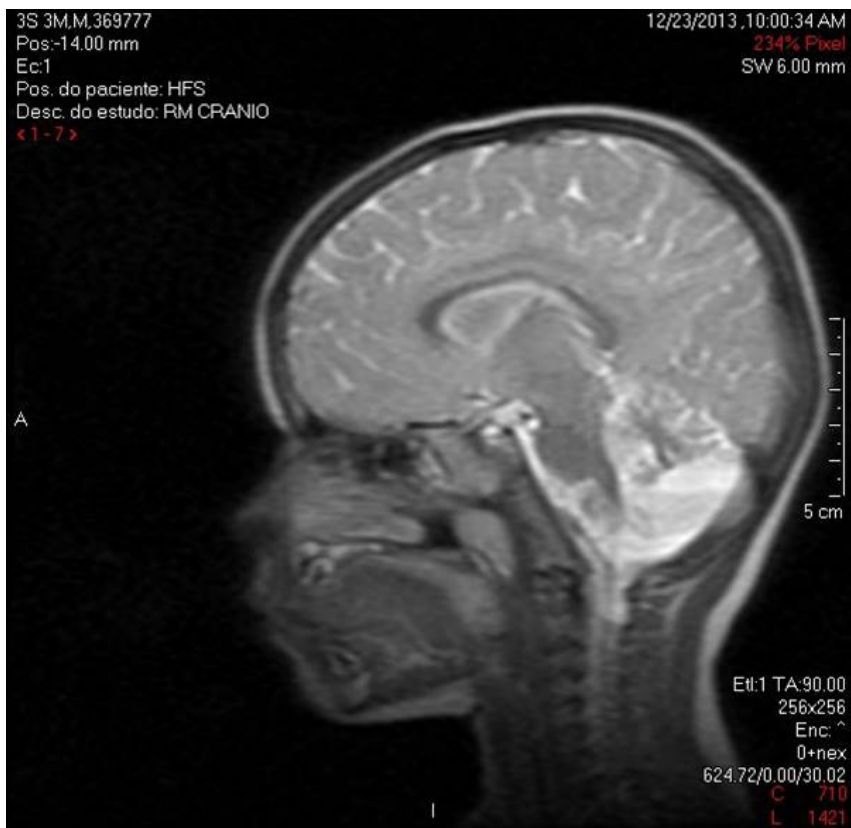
Magnetic resonance imaging, sagittal section evidencing cerebellar reduction and slight dilatation of the cisterna magna
